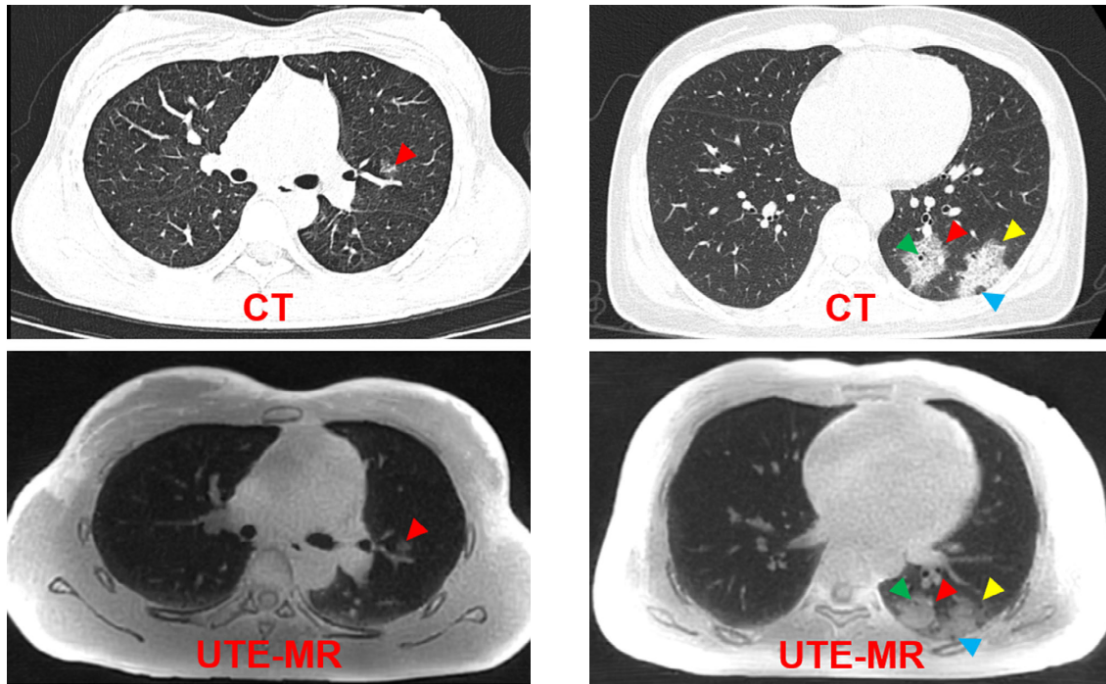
CT (top) and 3 T UTE MRI (bottom) axial slices in the lung of two COVID-19 patients (left and right). These figures are extracted from Jang *et al.*⁵⁹ The same radiological findings are found for both modalities: ground-glass opacities (red arrows), ground-glass opacities consolidation (yellow arrow), air bronchogram (green arrow), and pseudocavity (blue arrow). CT and UTE MRI present similar contrasts in the lung parenchyma, which can be associated to the soft tissue proton density. The UTE MRI image has a lower resolution but it is not ionizing.
